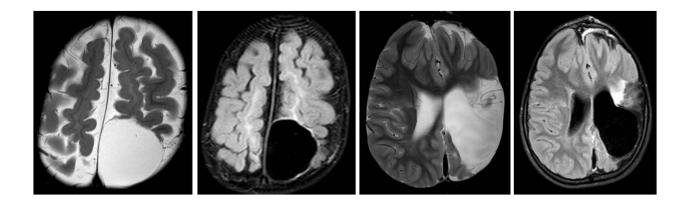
T2W axial and FLAIR images of two children with cystic encephalomalacia
